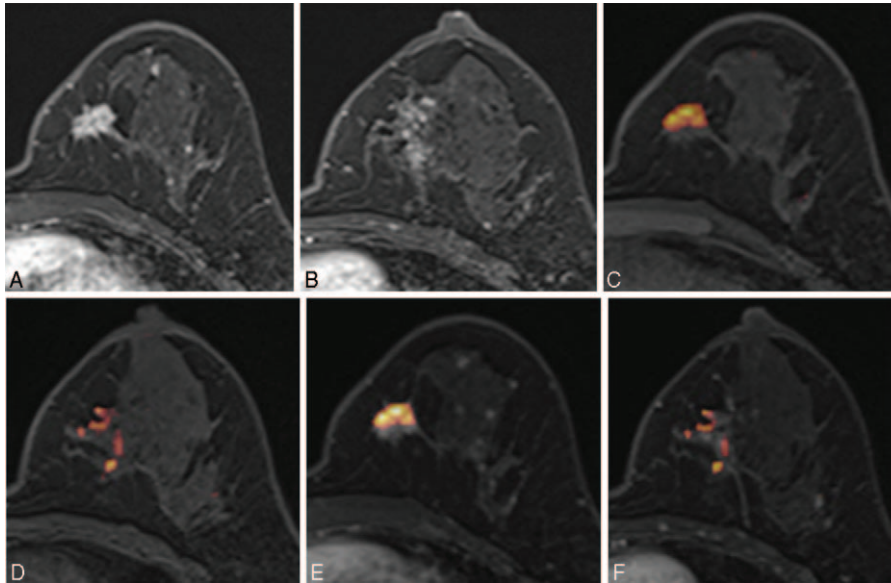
Images of a 44-y-old patient with an invasive ductal carcinoma of the left breast. (A, B) Axial DCE-MR images show an irregular enhancing mass in the lower inner quadrant and a focal nonmass enhancement at the level of the nipple of the left breast. (C, D) UFMR image shows a red-colored main mass, which was detected by all 5 readers, and a focal area of a red-colored nonmass lesion, which was detected by only 2 readers. (E, F) PCFMR image also shows a red-colored main mass and focal area of a red-colored nonmass lesion, which was detected by 3 readers. Surgery confirmed lobular carcinoma in situ and flat epithelial atypia. DCE-MR = dynamic contrast-enhanced magnetic resonance, PCFMR = fused diffusion-weighted imaging using early postcontrast T1-weighted imaging, UFMR = fused diffusion-weighted imaging using unenhanced T1-weighted imaging.
